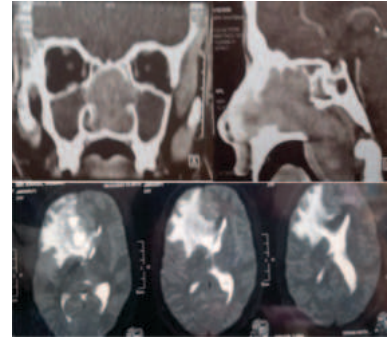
CE-MRI showing a right Basi frontal parafalcine mass compressing frontal lobe structures and extending through the cribriform late into the nasal cavity.
